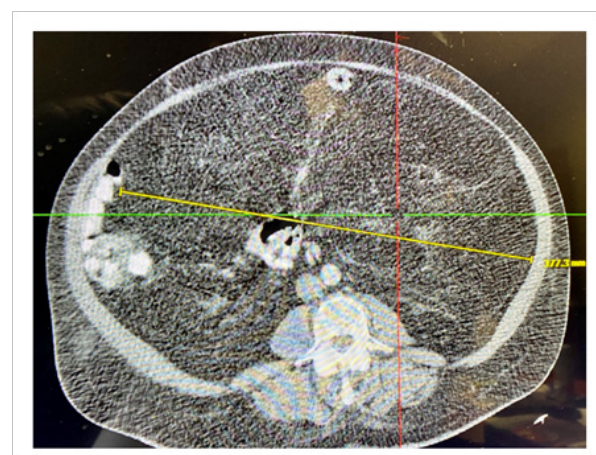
A CT scan of the abdomen.
